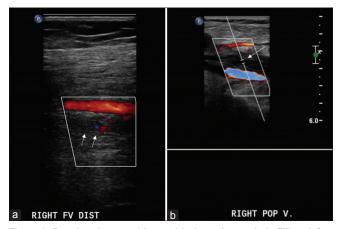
Doppler ultrasound image (a) shows hypoechoic filling defect (thin arrows) in the noncompressible distal right superficial femoral vein with no color flow, consistent with thrombus. Spectral Doppler image (b) shows the absence of waveform in the right popliteal vein (thin arrow) also consistent with thrombus
